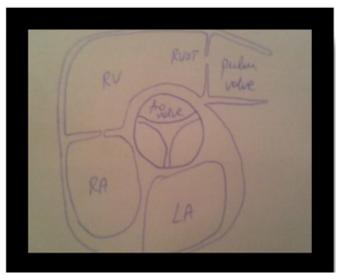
Bidimensional echocardiography. Parasternal short axis. AV=aortic valve; LA=left atrium; RA=right atrium, RV=right ventricle, RVOT=right ventricular outflow tract.
